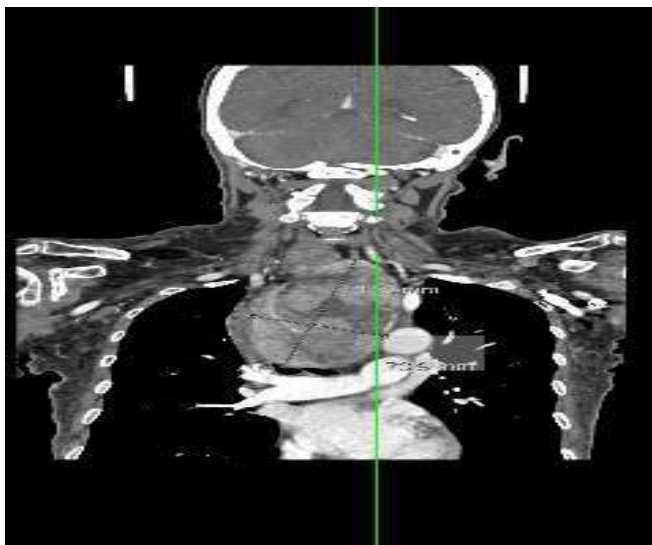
Preoperative axial CT scan.
